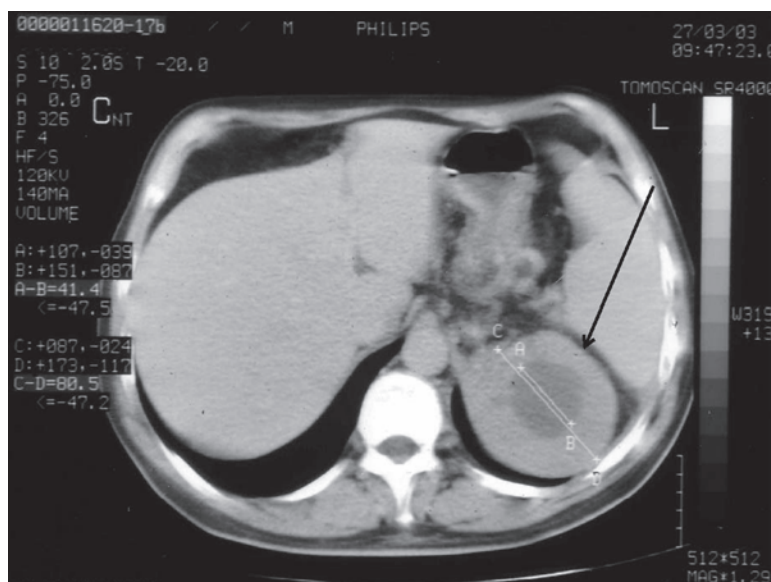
Computed tomography (CT) of the abdomen showing the tumor mass (10 × 7.5 cm) in the region of left adrenal (indicated with an arrow).
